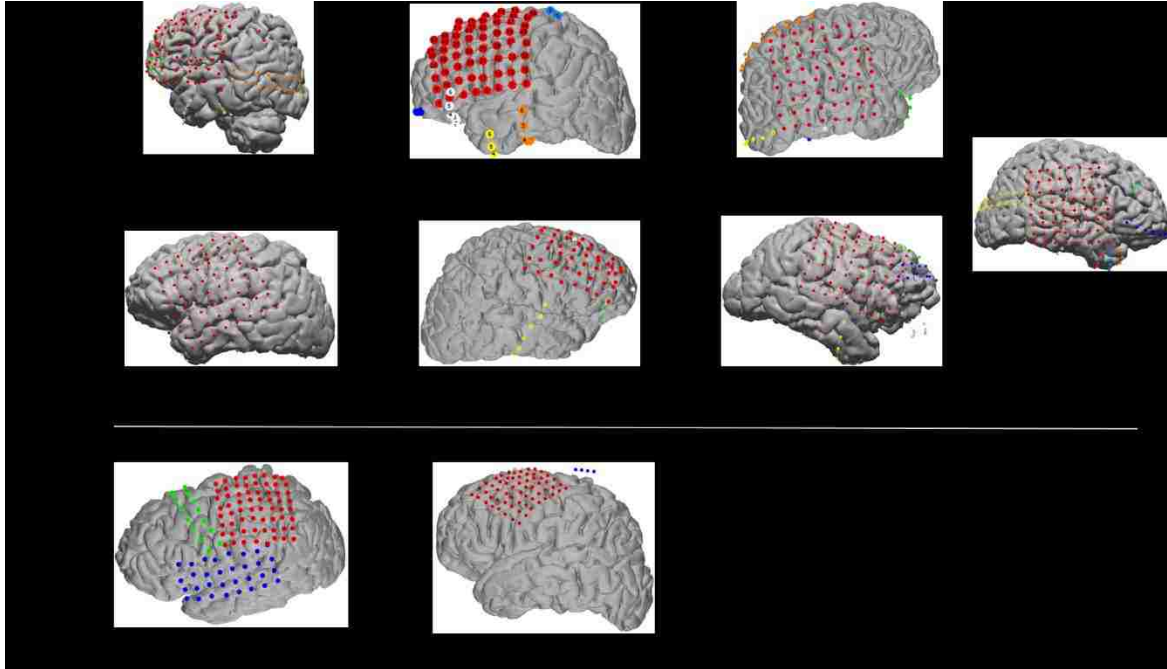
Clinical ECoG Implants by Subject. (a) Implant location for subjects with standard (1cm spacing) clinical ECoG arrays. Patient MR and CT scans were used to create 3D head model reconstructions showing the spatial arrangement of the implanted array in relation to the cortical tissue below. (b) Implant locations for subjects with 7.5mm spaced clinical arrays (in red).
